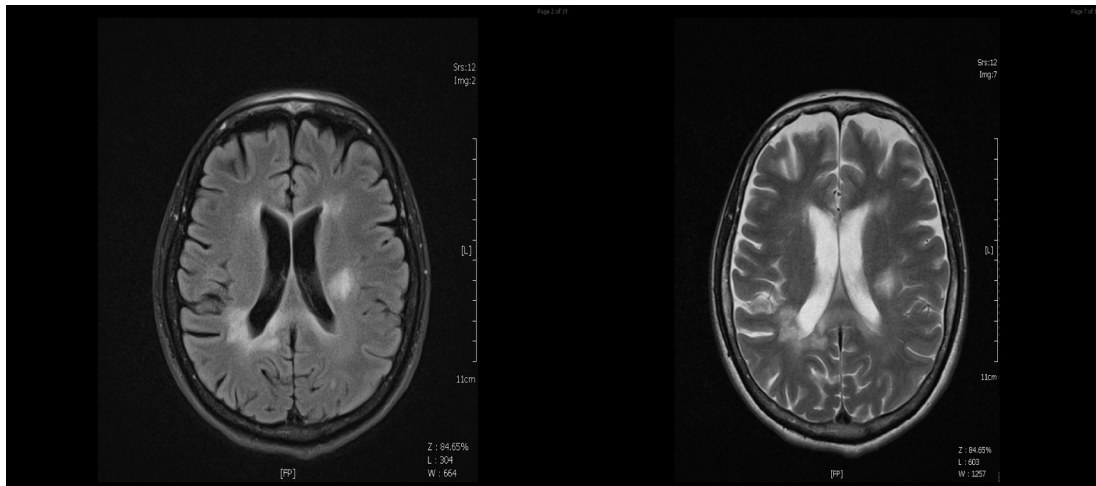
Brain MRI after 8 months did not show development of new T2 lesions and previously described lesions showed further regressive dynamics.
